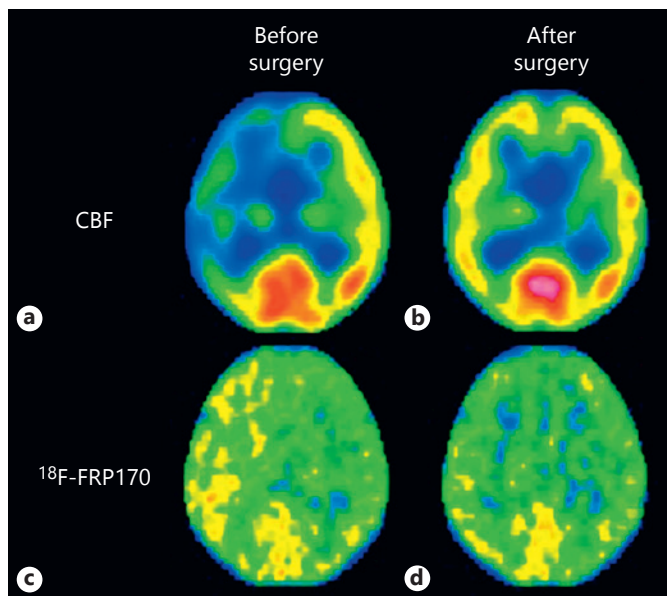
Brain perfusion single-photon emission computed tomography (a, b) and 1-(2-¹⁸F-fluoro-1-[hydroxymethyl]ethoxy)methyl-2-nitroimidazole (¹⁸F-FRP170) positron emission tomography (c, d) images from a 72-year-old man with symptomatic right cervical internal carotid artery stenosis and postoperative improved cognition. CBF and ¹⁸F-FRP170 accumulation are preoperatively reduced and increased, respectively, in the right cerebral hemisphere compared with the left cerebral hemisphere (a, c). These changes resolved after surgery (b, d). CBF, Cerebral blood flow.
